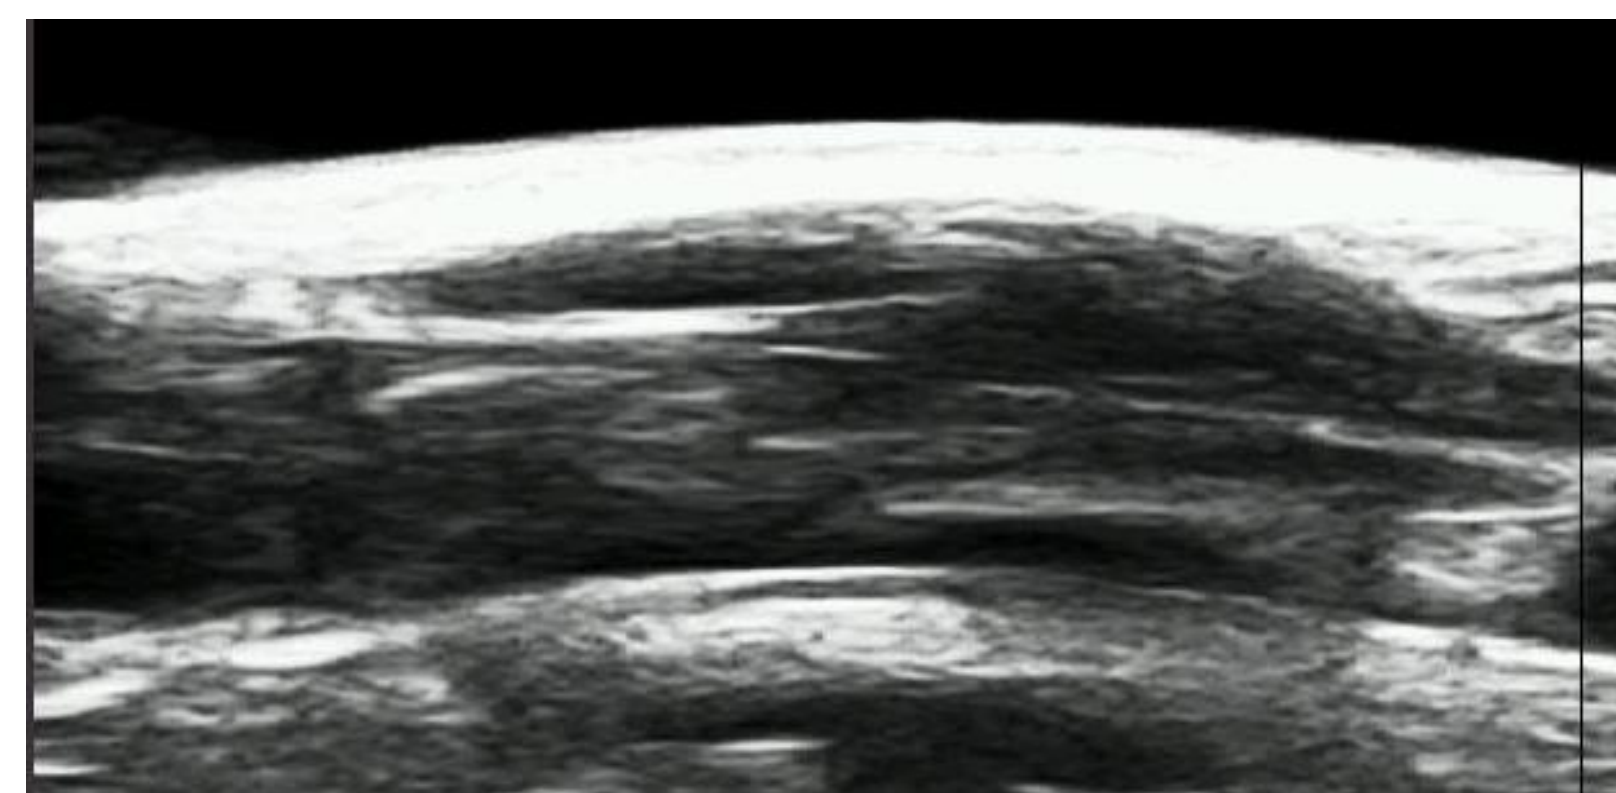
The corresponding frame from the ultrasound video was manually digitized to determine fascicle length assuming the angle formed by the deep and superficial aponeurosis of the distal muscle belly was representative of fascicle pennation angle. [3].
